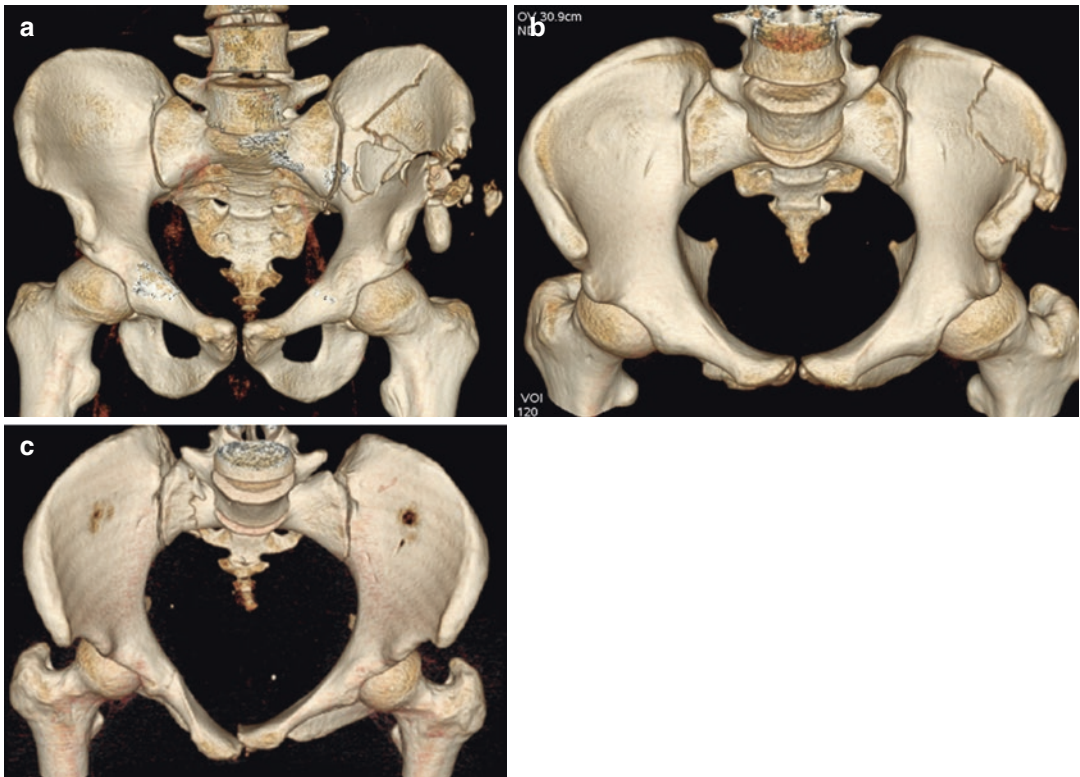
(a–c) Lateral compression fractures (LC), type I. (a, b) CT 3D (VR) reconstruction AP and inlet view show lateral force vector, resulting in fracture of the left iliac wing on the side of the impact. (c) CT 3D (VR) reconstruction inlet view shows a “locked symphysis”
